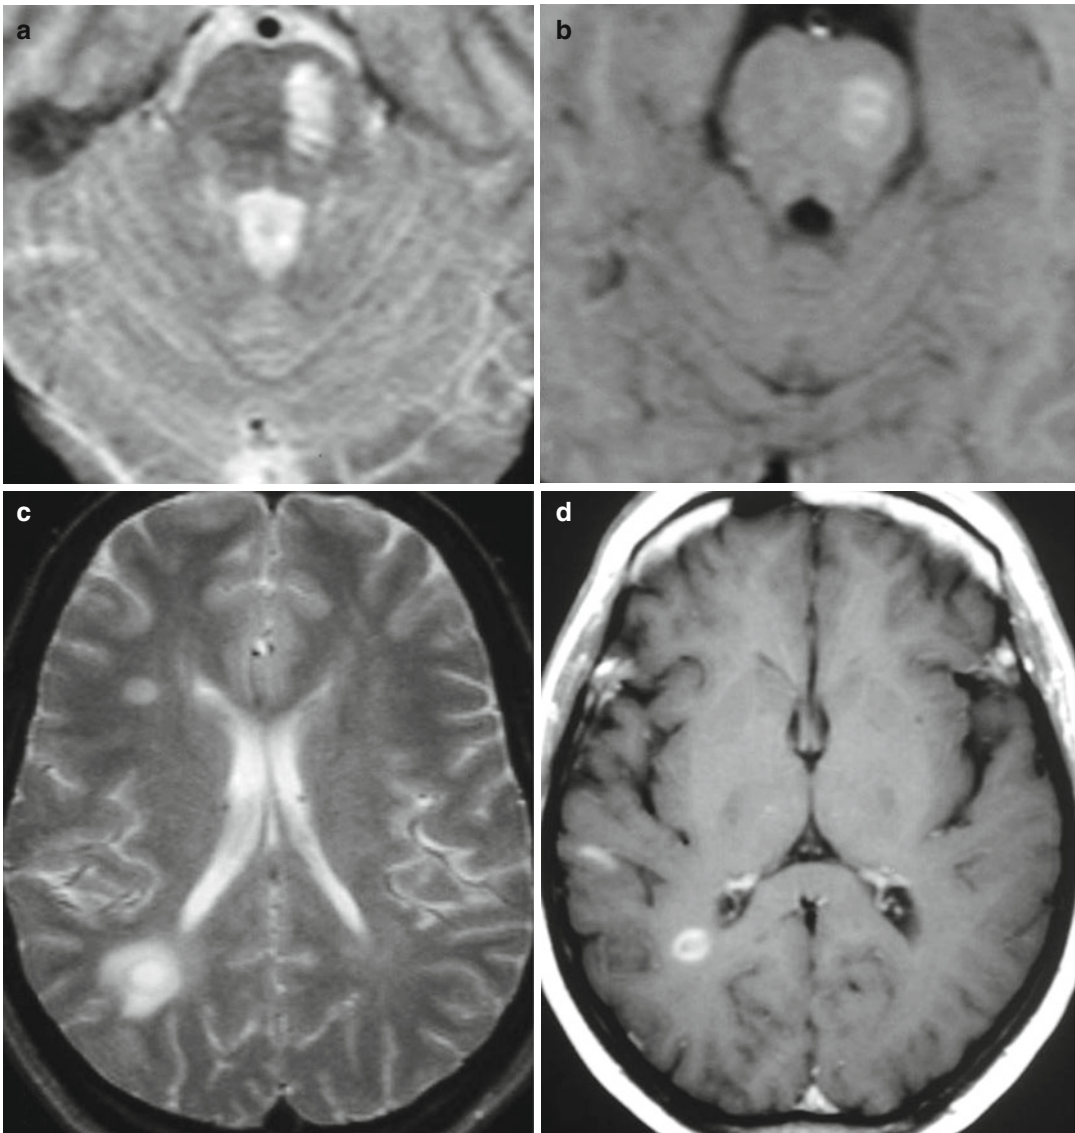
MS, acute phase. T2-weighted image, (a, c) demonstrate focal hyperintensities in the left pons and in the white matter of the right hemisphere, respectively;
